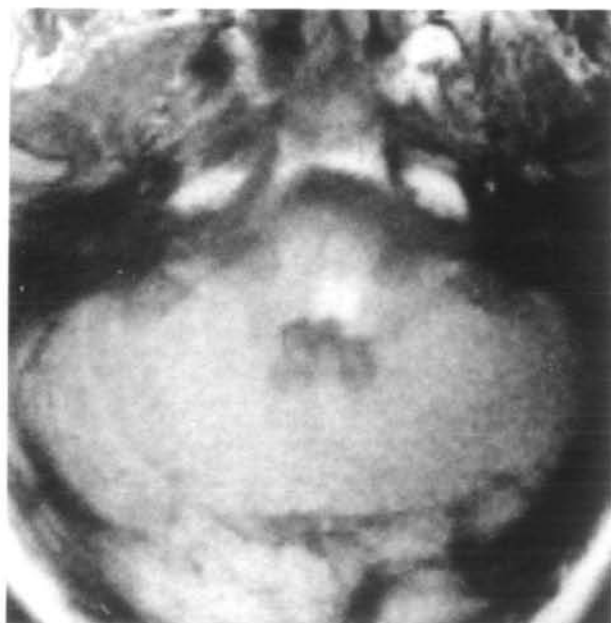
Axial T<sub>1</sub>-weighted (repetition time, 520 milliseconds; echo time, 26 milliseconds) magnetic resonance imaging scan of a hemorrhage in the left medial medullary region with mild ventral extension.
